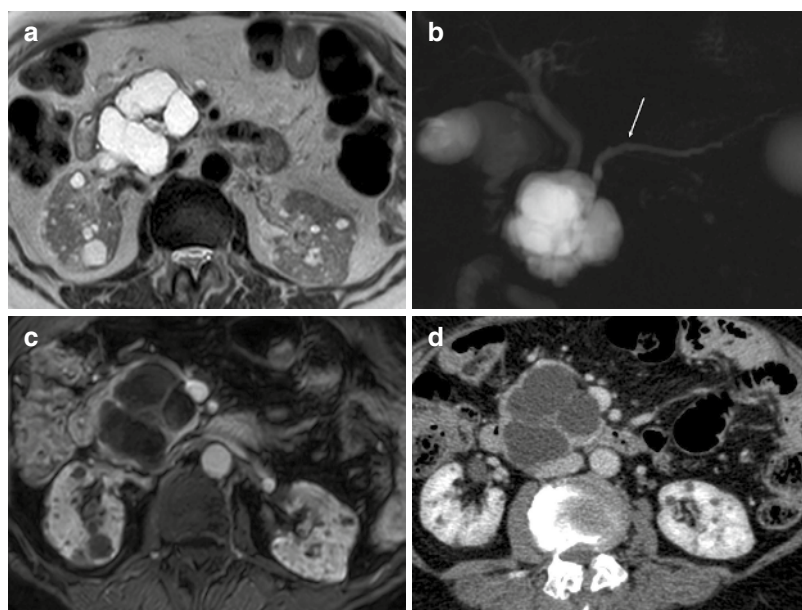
A 75-year-old woman with a microcystic serous cystadenoma in the pancreatic head. (a) Axial T2-weighted image shows a lobulated cystic lesion with multiple hypointense septa oriented toward a central scar.
